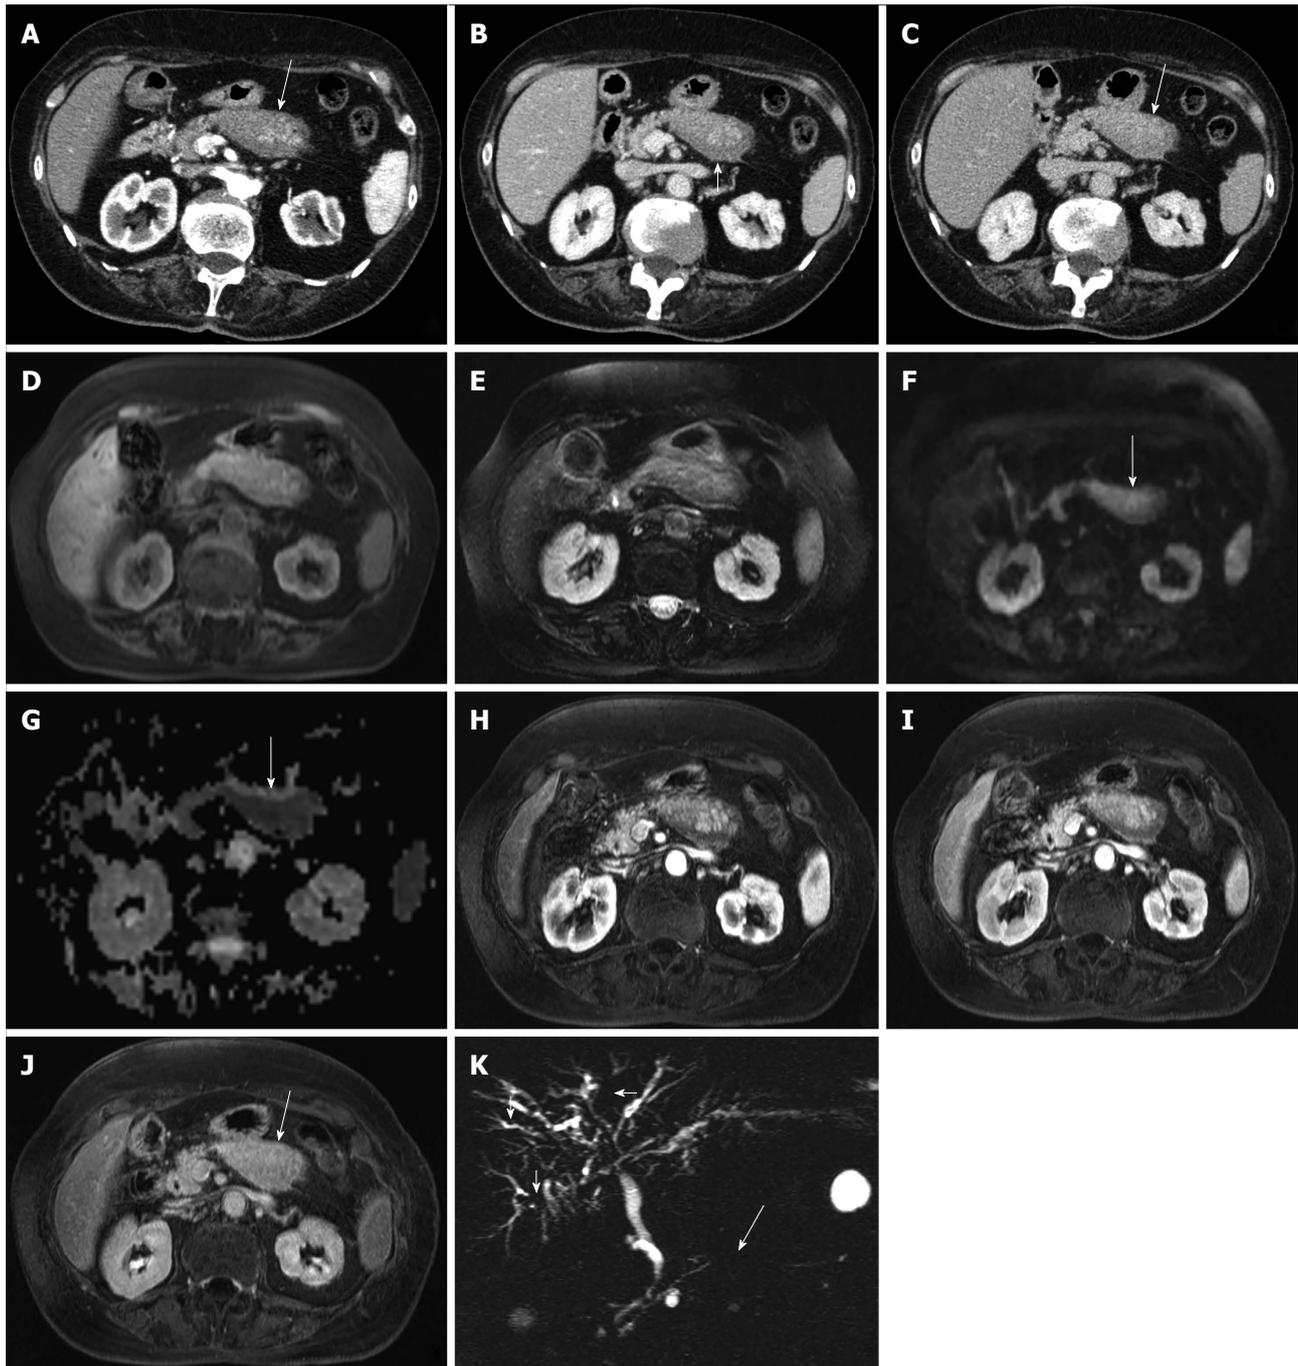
Focal-type autoimmune pancreatitis. A-C: Computed tomography: the body of the pancreas appears focally enlarged (arrow in A) with a hypodense peri-pancreatic rim, better visible in the venous phase (arrow in B). The lesion shows fair enhancement resulting almost isodense in the delayed phase (arrow in C); D-K: Magnetic resonance: the affected portion of the pancreas is slightly hypointense on T1-weighted fat-saturated (arrow in D) images and slightly hyperintense on T2-weighted fat-saturated images (E), with diffusion coefficient restriction (arrows in F-G) with intermediate-high b values. At dynamic examination the pancreatic lesion shows fair enhancement resulting almost isodense in the delayed phase (arrow in J). At magnetic resonance cholangiopancreatography the main pancreatic duct shows a focal stenosis (long arrow in K) without upstream dilation. The intrahepatic bile ducts present irregular slightly stenotic portions (short arrows in K), due to involvement in the autoimmune process.
